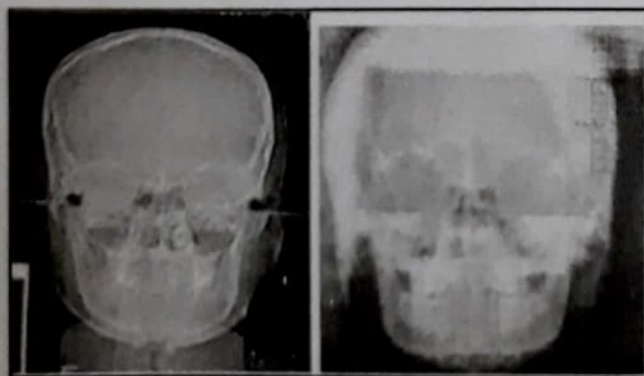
Measurement of frontal ramal inclination in CT and PA ceph.
